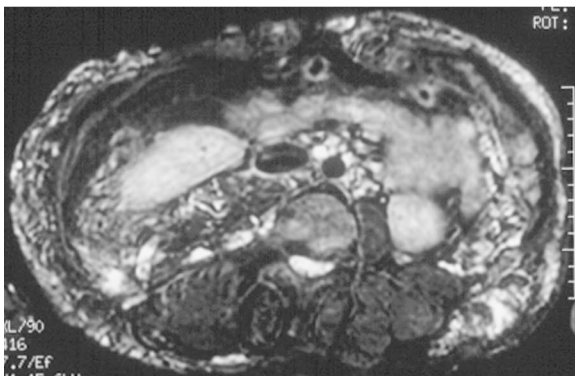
Fatty infiltration of muscles, and vascular malformations. (a, b) Axial nonenhanced CT images of the thorax (a) and abdomen (b) in a patient aged 14 years show thoracic deformity, including a large asymmetric area with the attenuation of fat along the posterior chest wall and infiltrating the paraspinal muscles bilaterally (arrows), more noticeable in the left side than in the right, which causes elevation of the left scapula away from the posterior chest wall (arrowhead in a); less prominent fatty infiltration along the left lateral chest wall and in the muscles of the anterior chest wall, as well as the posterior, lateral, and anterior abdominal wall and the left anterior rectus abdominis muscle; and enlargement of the right psoas muscle with fatty infiltration that surrounds multiple serpentine blood vessels. (c) Axial MR image obtained with a short inversion time inversion recovery, or STIR, sequence at a level similar to that in b, shows vascular malformations within the fatty tissue in the retroperitoneum, right psoas muscle, and abdominal wall.
